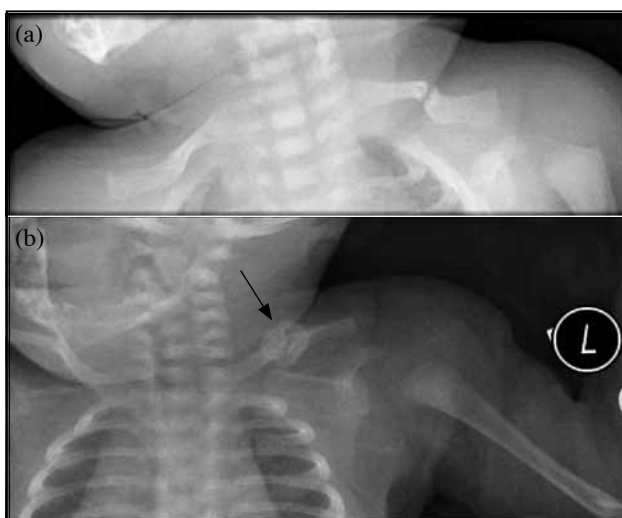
(a) Radiograph taken on day 4 of life showing the left-sided clavicular fracture. (b) Radiograph taken on day 18 of life showing an obvious callus (arrow) over left-sided fracture site
